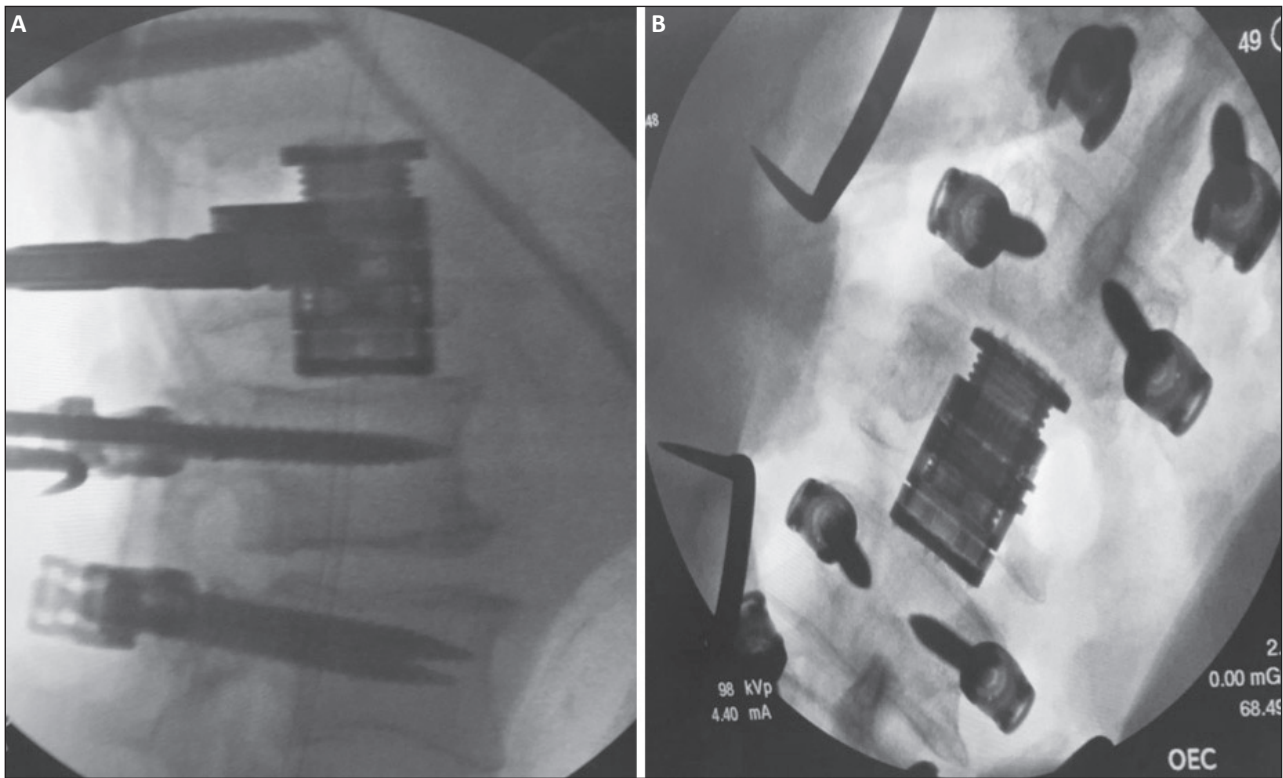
Reconstruction of the anterior column of the thoracolumbar spine with an expandable cage: A. lateral x-ray; B. anterior/posterior x-ray.
